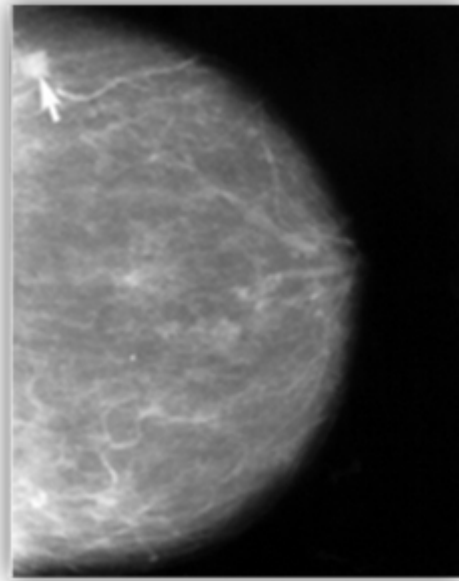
Breast cancer on x-ray image [9.]
